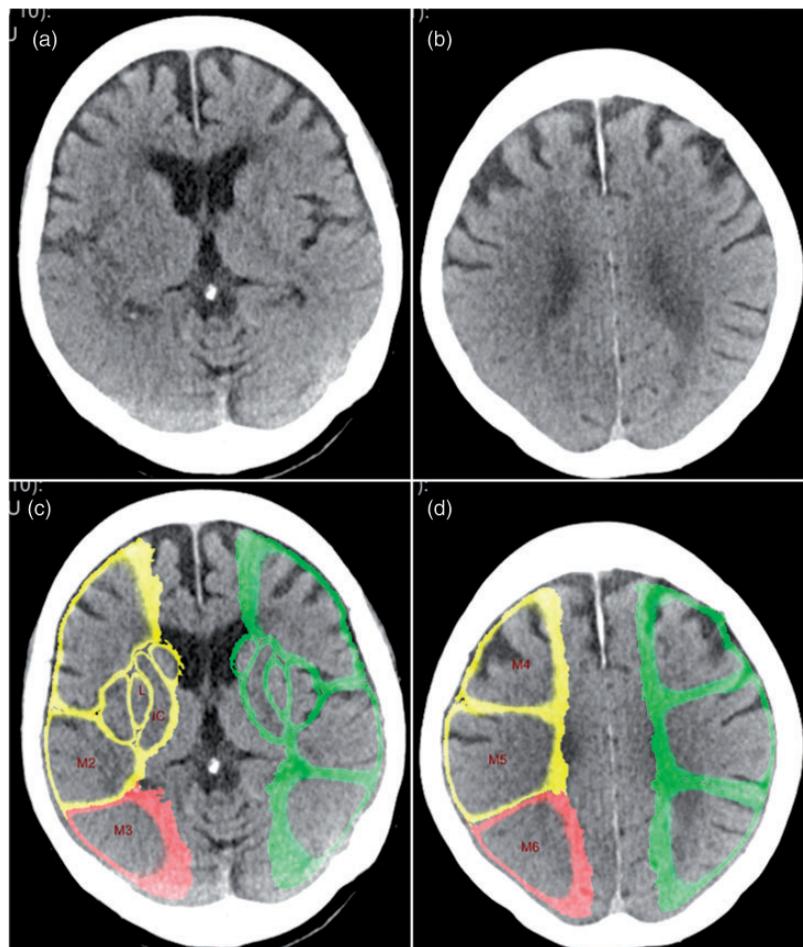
(a–d) Excellent agreement in early ischemic change detection (in the right M3 and M6 region, marked in red) between Frontier_ASPECTS (c, d) and expert consensus reading in a 78-year-old woman with acute left hemiparesis due to right middle cerebral artery occlusion.
